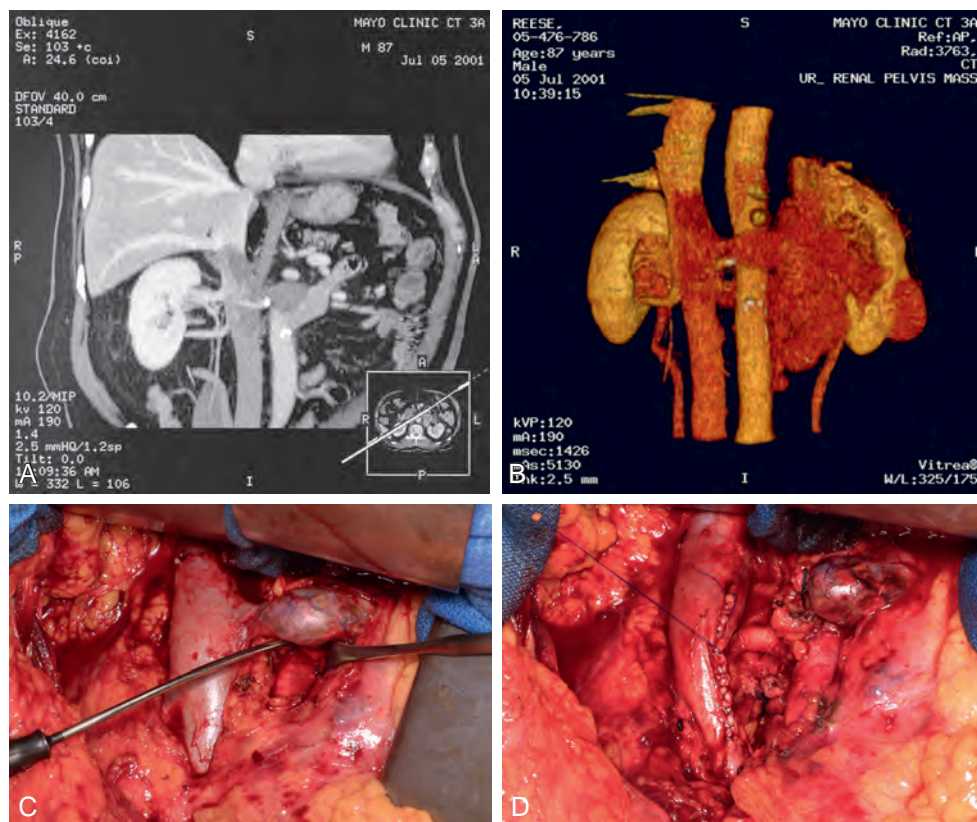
Coronal computed tomography scan (A) and three-dimensional reconstruction (B) of a level II left-sided tumor thrombus. C, Securing vascular control. D, Repair of inferior vena cava defect.
